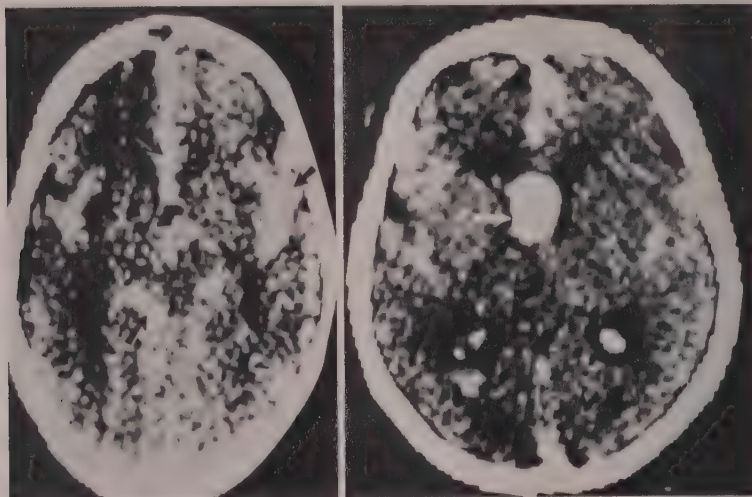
Computed tomography may demonstrate (left) subarachnoid blood in unenhanced scan (arrows) and (right) anterior communicating aneurysm filling on enhanced scan (arrow).
